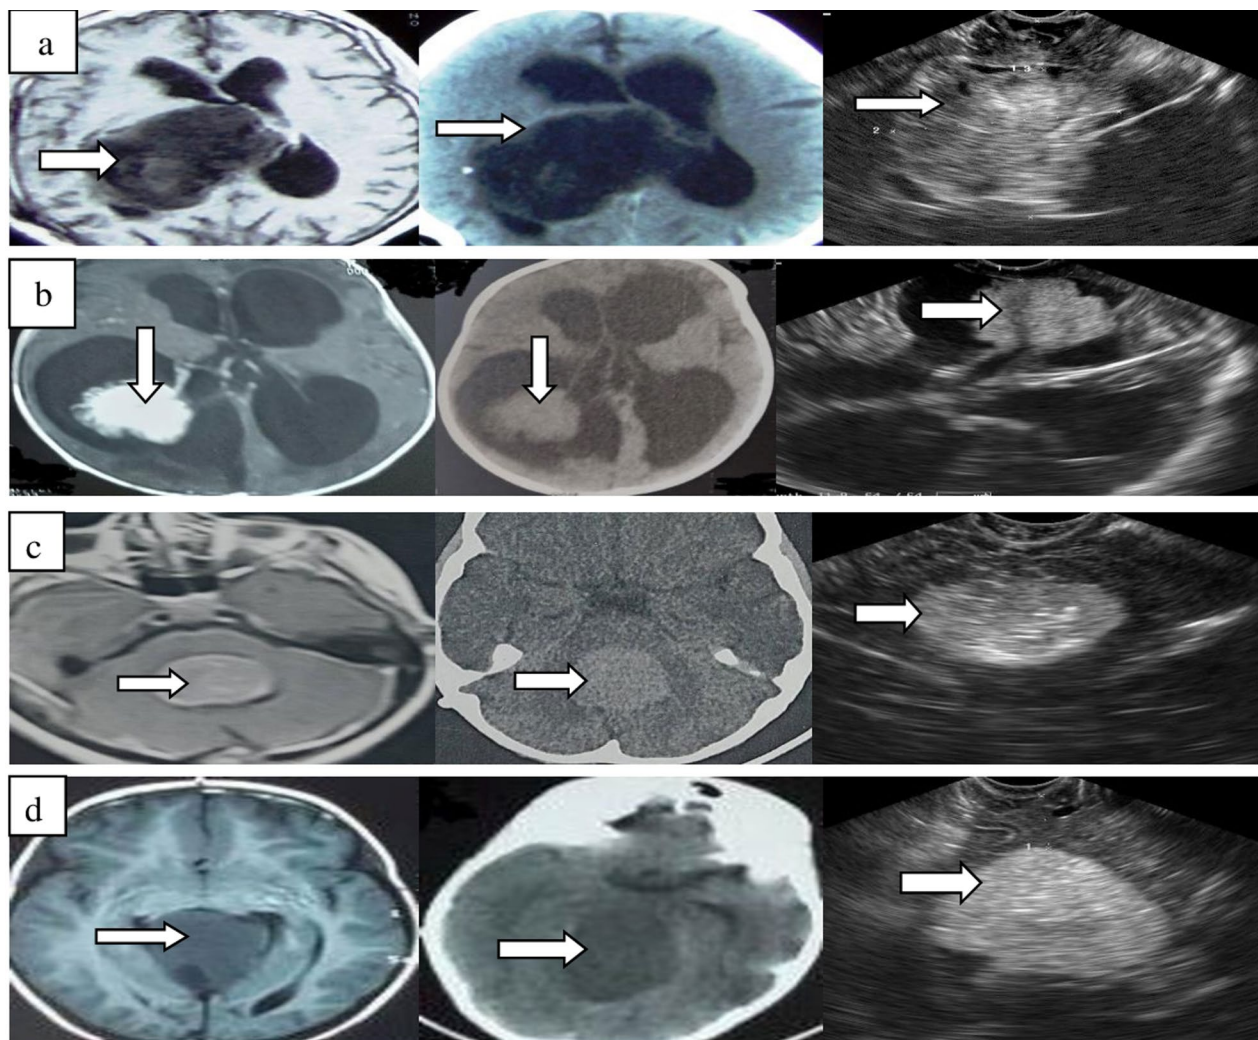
Imaging of intraventricular tumors by MRI T1, CT and IOUS. White arrows refer to the tumor. Case a: Intraventricular epidermoid tumor; hypo-intense in MRI T1, hypo-dense in CT, and heterogeneous echogenicity in IOUS. Case b: Intraventricular choroid plexus papilloma; homogenous enhancement in MRI T1, hypo-dense in CT and homogenous hyper-echogenicity in IOUS. Case c: Intraventricular ependymoma; heterogeneous enhancement in MRI T1, hyper-dense in CT and heterogeneous echogenicity in IOUS. Case d: Intraventricular medulloblastoma; hypo-intense in MRI T1, hyper-dense in CT, and homogenous hyper-echogenic in IOUS
